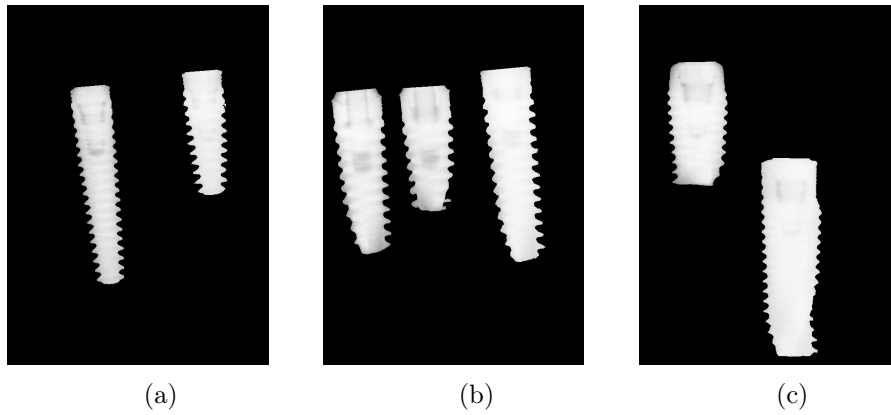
Actual X-ray images after the application of ROI-masking.
